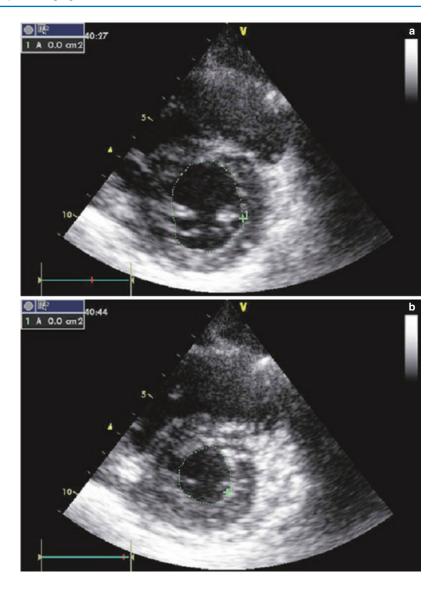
Parasternal short-axis view (TTE). (a) LV end-diastolic area. (b) LV end-systolic area. (From Sarti with permission)
